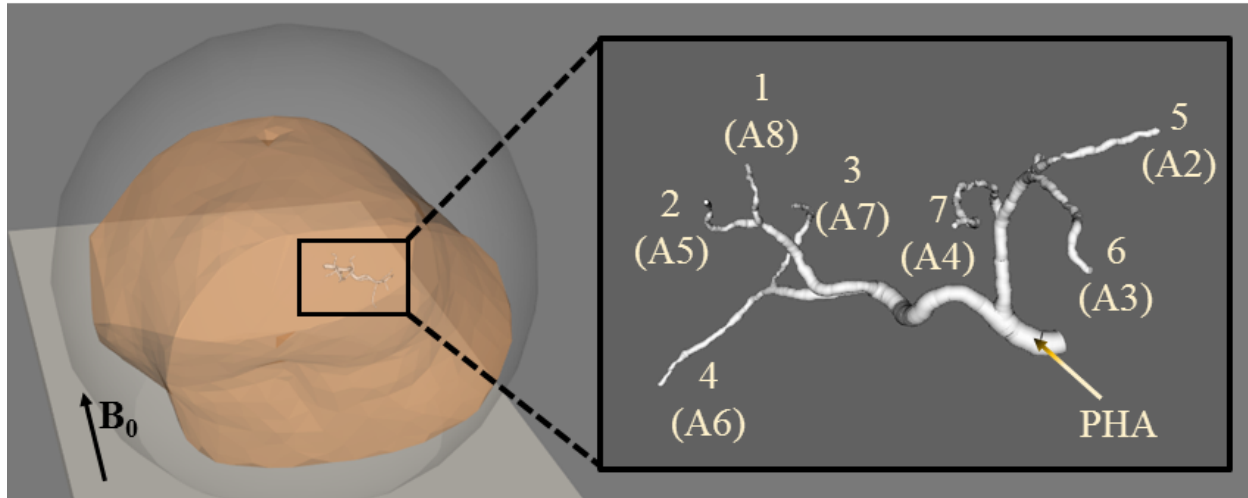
Realistic scenario tested for DFN in a real human liver model, taking into account the limited space around the patient body inside an MRI scanner. The transparent sphere represents the homogeneous field volume of a conventional scanner. Vascular routes are numbered for the tests, with the corresponding segmental arteries (Couinaud classification) in parentheses.
